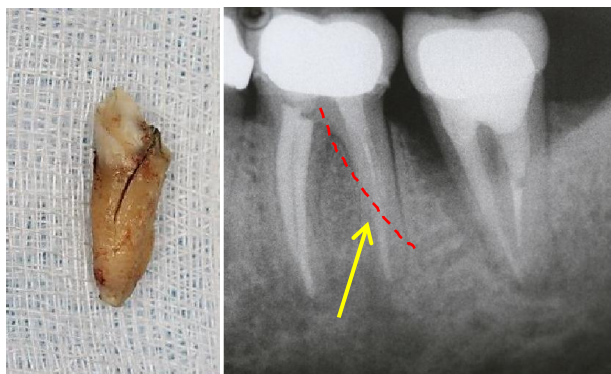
a/fracture line; b/radiographic sign of fracture of mesial root of mandibular molar
